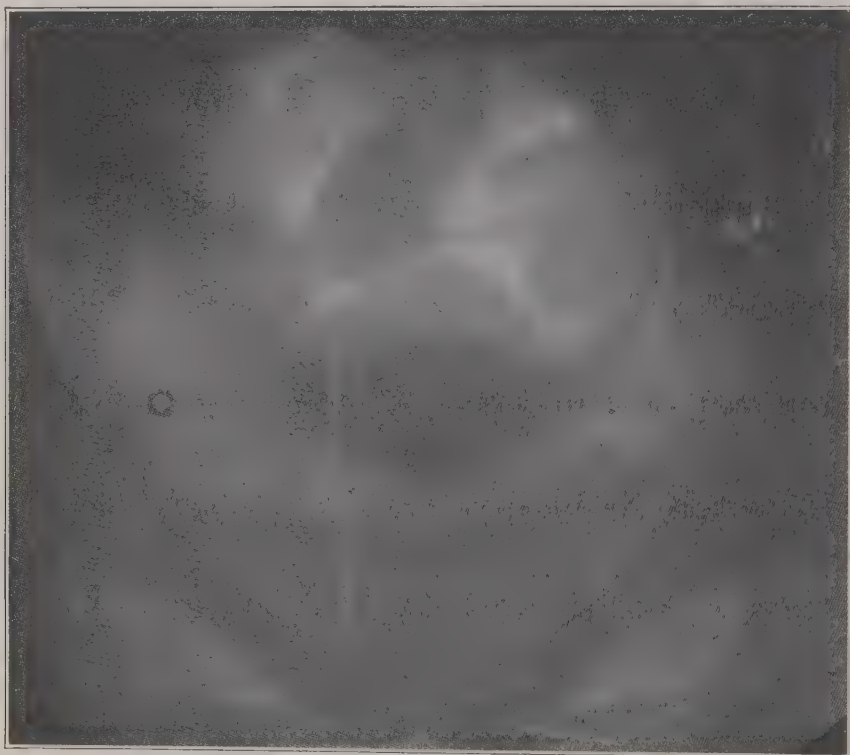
Pneumoperitoneum, x-ray plate, normal pelvis. (Peterson—*Am. Jour. Roentgenology*.)
